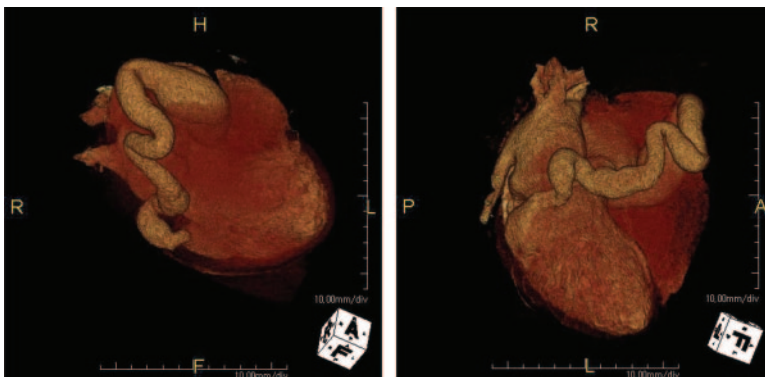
Three-dimensional volume-rendered CT images provide arbitrary optimal views of the spatial orientation and dimension of the huge dilated, tortuous RCA draining into the posterior aspect of the LV through a large fistula.
